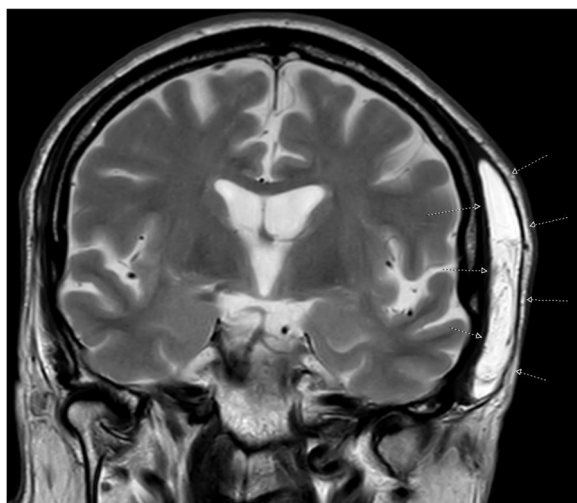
Coronal T2-weighted MRI image shows prominent low signal foci in the mass lesion
